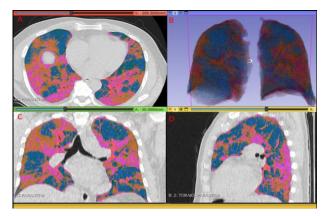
Regional colour coding and volumetric analysis of lung parenchyma according to HU values. A: Axial CT scan presenting the lungs with color-coded regions that indicate the distribution of varying HU values within the lung parenchyma, offering insight into the extent and pattern of involvement. B: 3D volumetric rendering of the lungs with the entire parenchyma color-coded according to the HU values, giving a comprehensive view of the distribution of different tissue densities. C-D: Coronal and sagittal CT scan of the lungs with multiple regions color-coded based on different HU values, highlighting variations in tissue density across the lung parenchyma
